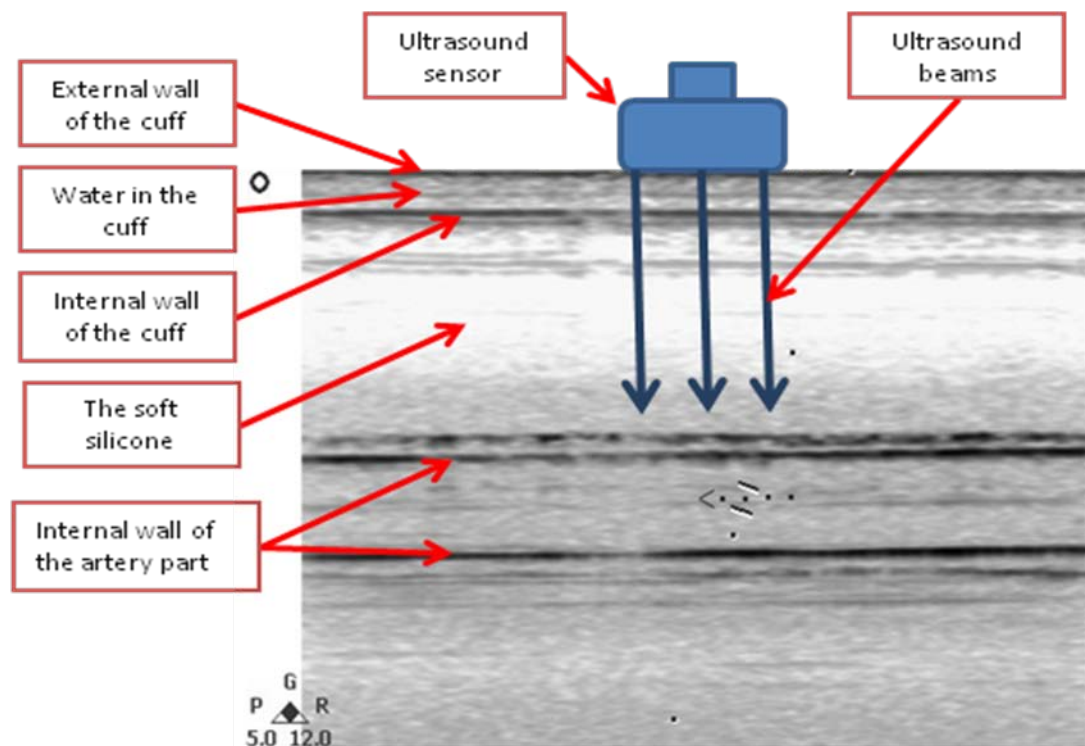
Ultrasound image in coronal plane
